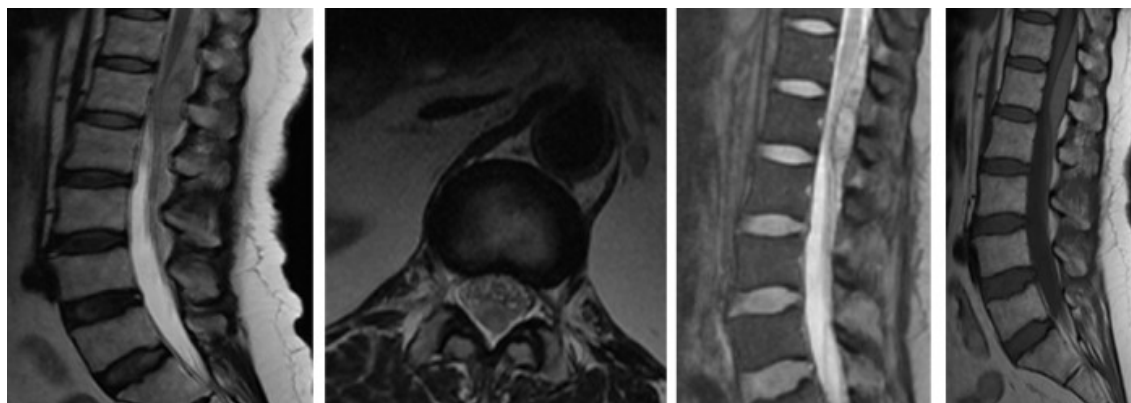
MRI showing epidural hematoma.
